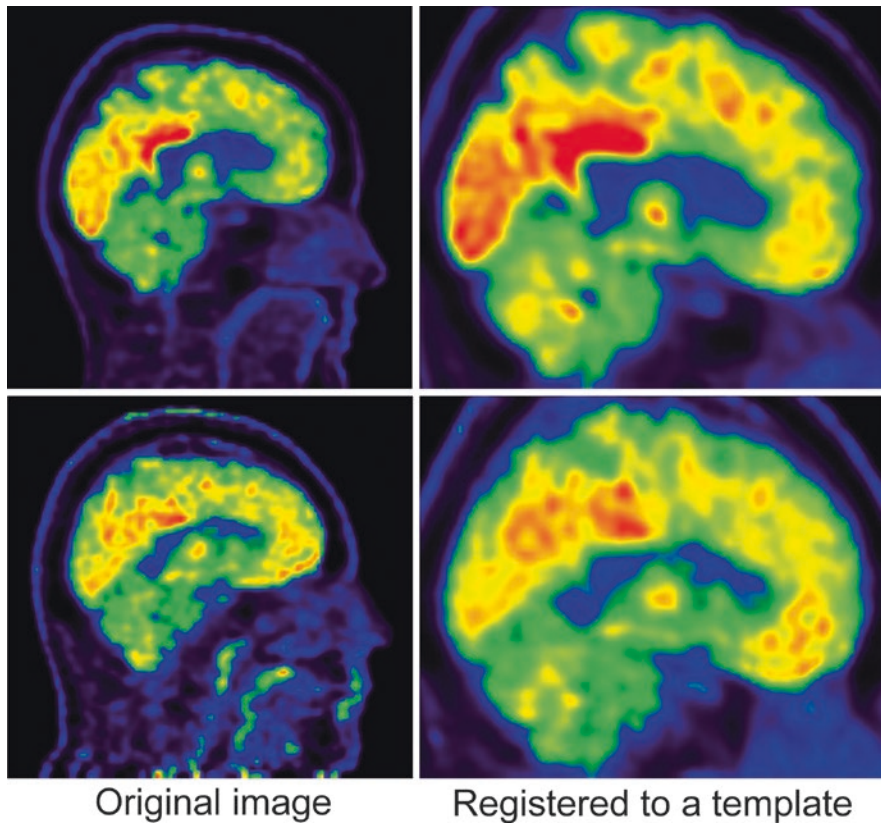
Example of two healthy controls showing the reconstructed ^{18}F -FDG PET image, and the images after registration to an ^{18}F -FDG PET specific template in standard space (Della Rosa et al. 2014)
